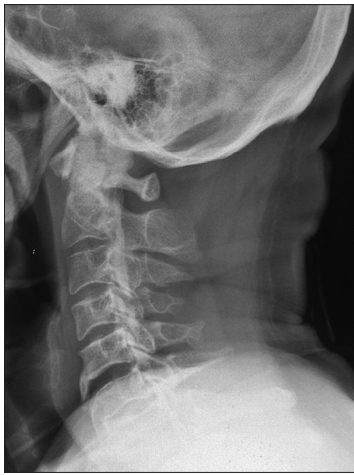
X-ray showing cervical spine ossified posterior longitudinal ligament
